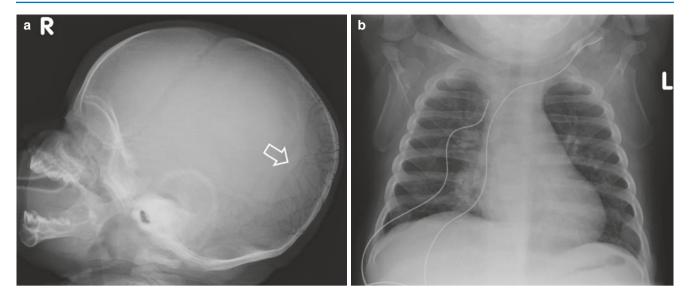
Six-month-old infant diagnosed with Menkes disease. (a) Lateral radiograph of the skull shows multiple wormian bones (arrow). (b) AP chest radiograph shows cupping/flaring of the ribs
